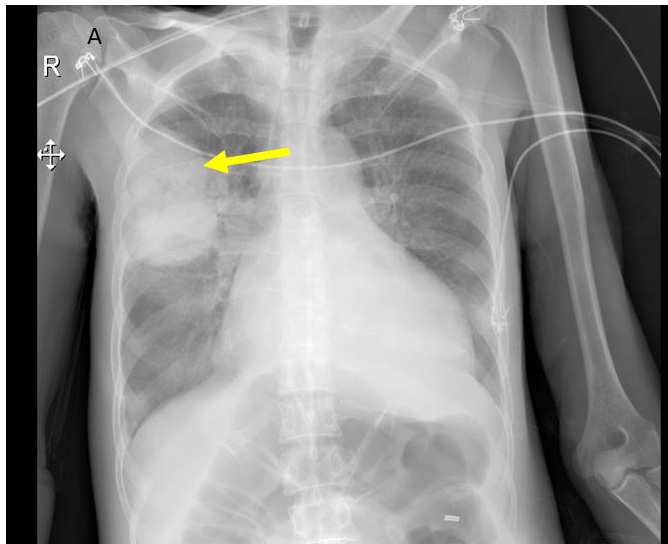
Chest X-ray showing the presence of wedge-shaped opacity of right middle lobe (Yellow Arrow).
